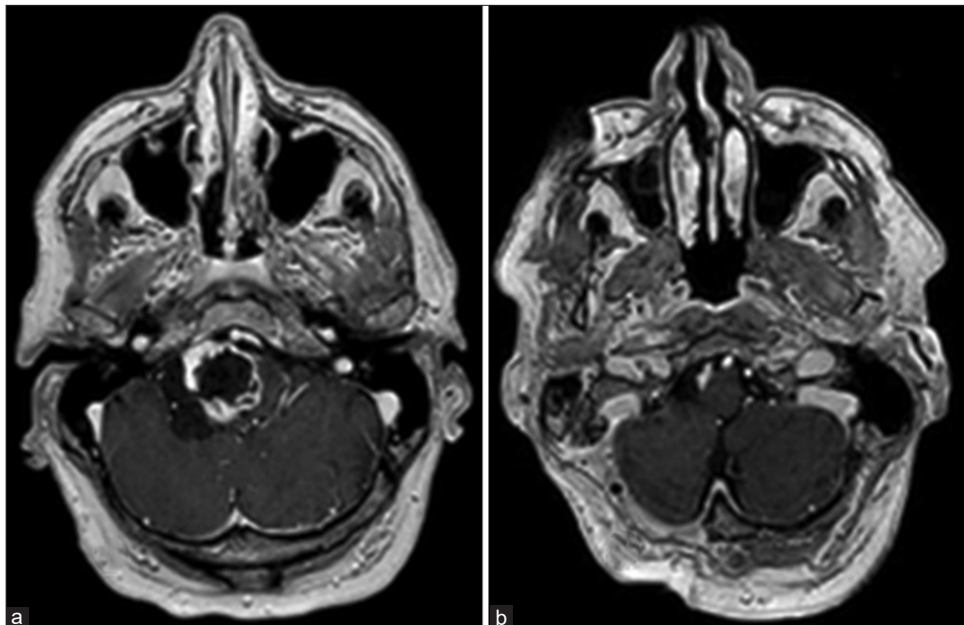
Radiological examinations: (a) preoperative axial T1-weighted contrast-enhanced MRI demonstrating a rim-enhancing lesion. (b) Postoperative axial T1-weighted contrast-enhanced MRI showing the thin layer of tumor left at surgery.
